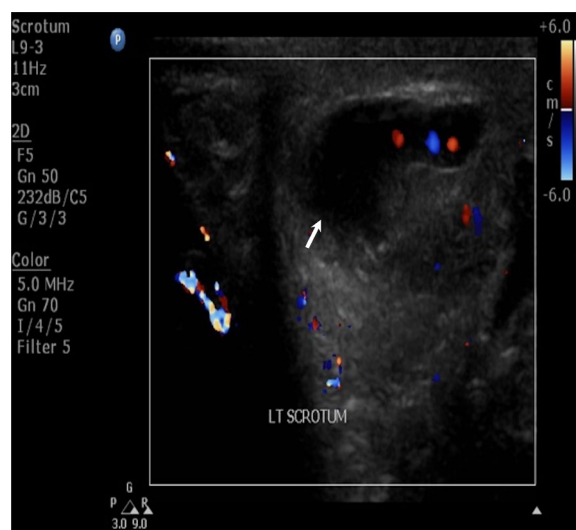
Ultrasound (longitudinal view) shows heterogeneous (arrow) and enlarged left testis
